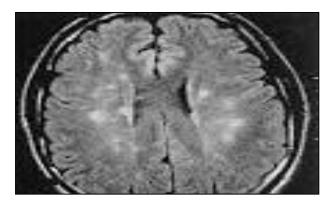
Fluid attenuated inversion recovery MR image of brain showing multiple focal lesions in periventricular and deep white matter characteristic of cerebral FES.²⁴
